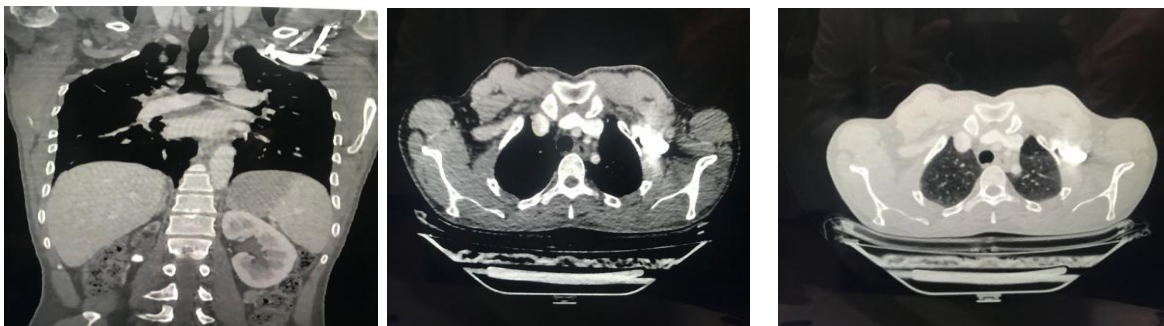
High Resolution CT scan of Lungs
